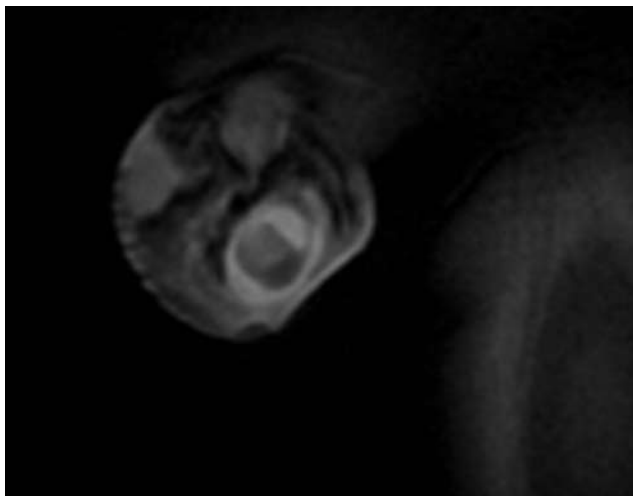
Dynamic contrast enhanced MRI image of testicles of a patient with left-sided torsion of the testicular appendage. Uptake of the gadolinium is enhanced around the left testicle. The testicles themselves show equal signal intensity.
